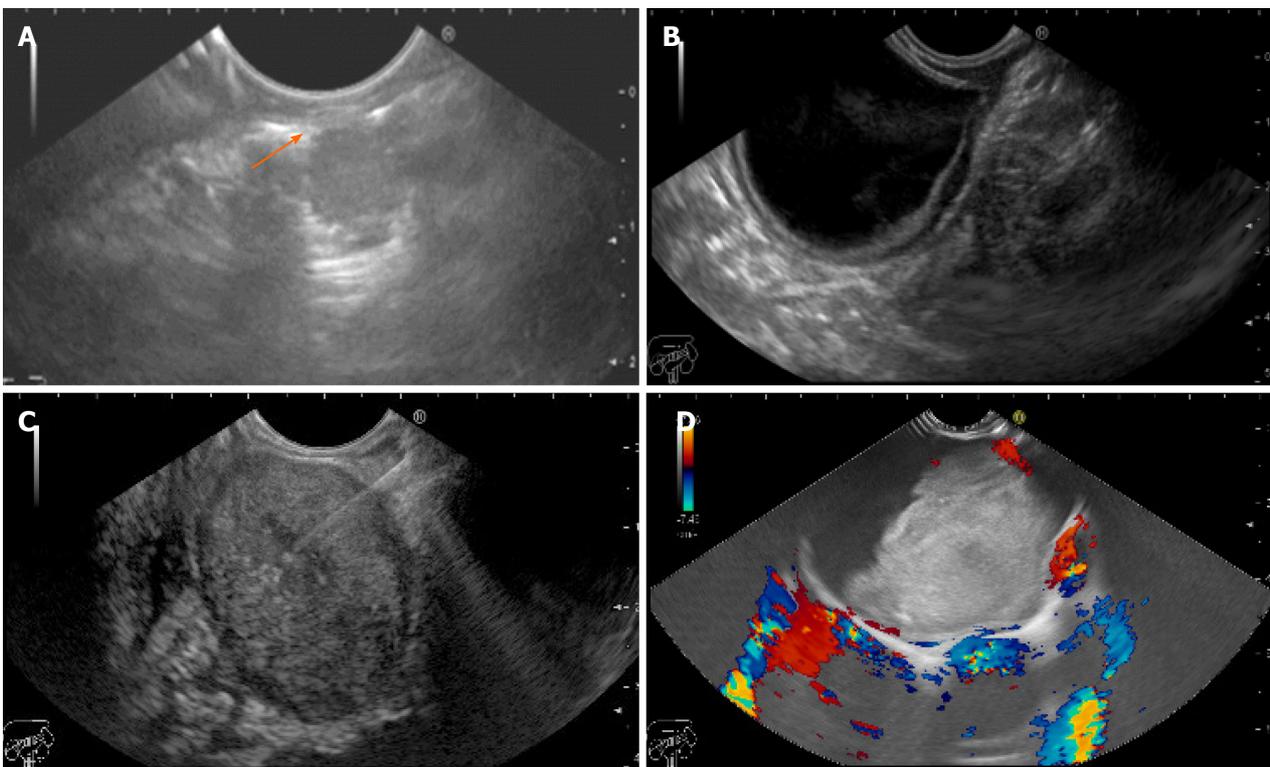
Endoscopic ultrasound. A: Tracheal fibroma separable from the esophageal wall (arrow); B: Antral duplication cyst; C: Rectal gastrointestinal stromal tumor with fine needle aspiration; and D: Mediastinal bronchogenic cyst.
